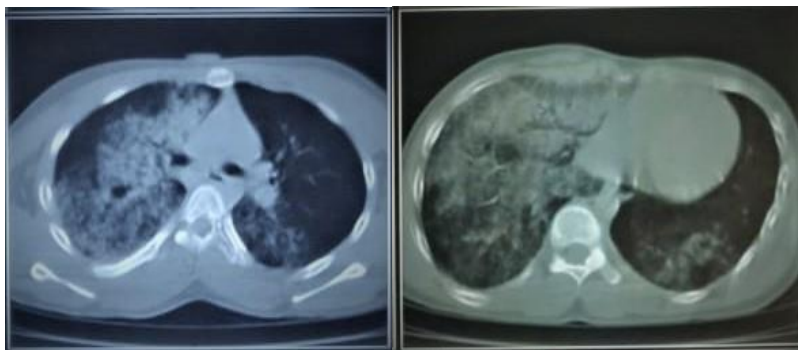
& 3 CT Chest shows – Centrally distributed Ground glass opacities involving Right upper, middle and lower lobe, and left Perihilar & Lower lobe.
